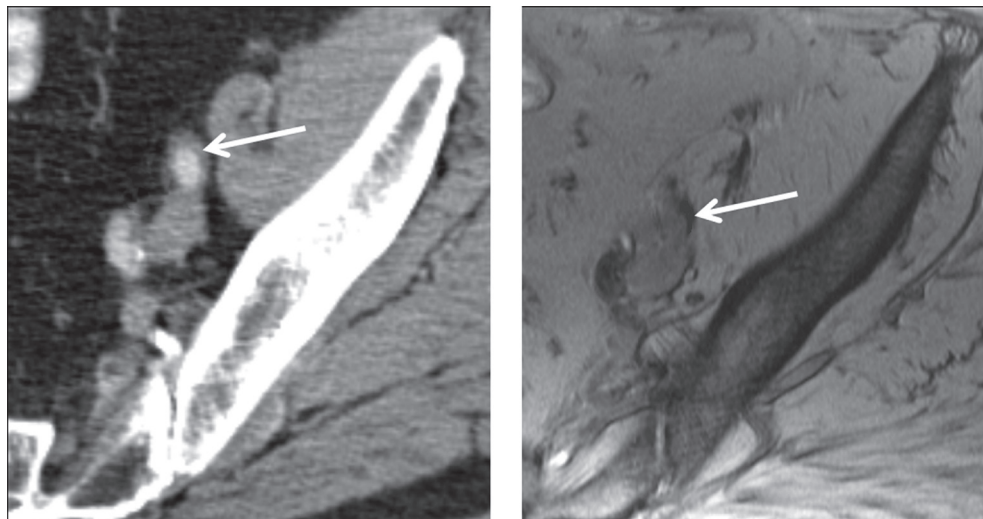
USPIO uptake in the wall of the left External Iliac Artery. The right panel (T2*-weighted MR sequence) shows a subendothelial signal void not attributable to calcification or intramural haematoma on CT (left). Note similar drops in signal intensity as a result of calcium in the Ilium and Sacrum.
